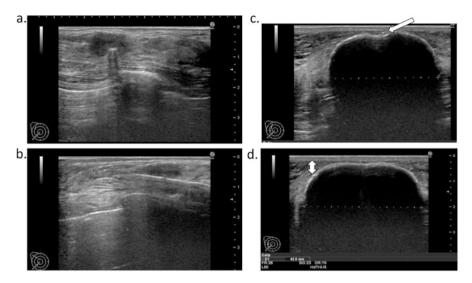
Finding a way to perform cryoablation in thin thickness breasts. (a) Ultrasonography with transverse axis of the probe before freezing. The probe was inserted into the dorsal part of the lesion because of assurance of cancer extirpation of dorsal part. (b) Ultrasonography with longitudinal axis of the probe before freezing. The probe was inserted into the dorsal part of the lesion because of assurance of cancer extirpation of dorsal part. (c) Ultrasonography with transverse axis of the probe after freezing. Growing ice ball adjacent to the skin was accurately observed. 23G needle, injecting saline, was identified (*white arrow*). (d) Ultrasonography with transverse axis of the probe after freezing. End of second freezing. Size of the ice ball along transverse axis was 42.5 mm. Gap between the skin and the fascia is more than 5 mm
